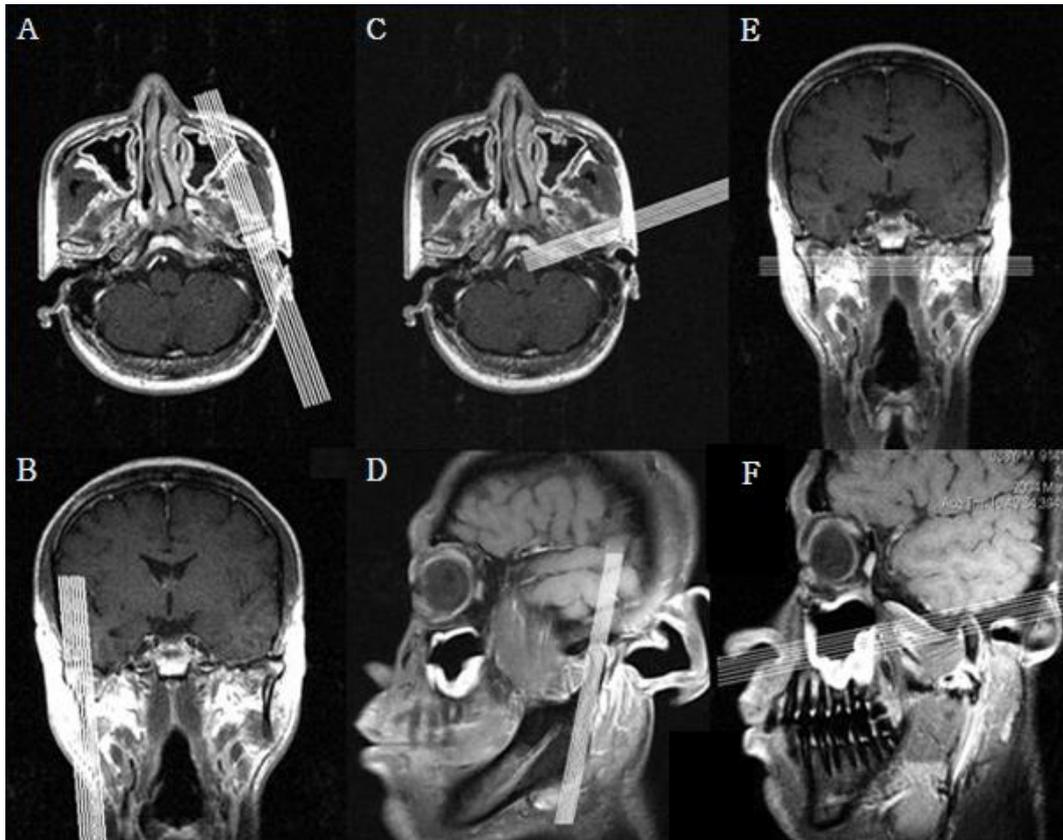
MRI sections for TMD. All participants had taken several sections of MRI for TMD evaluation. (A, B: Para-sagittal section, C, D: Para-coronal section, E, F: Para-transverse section)
